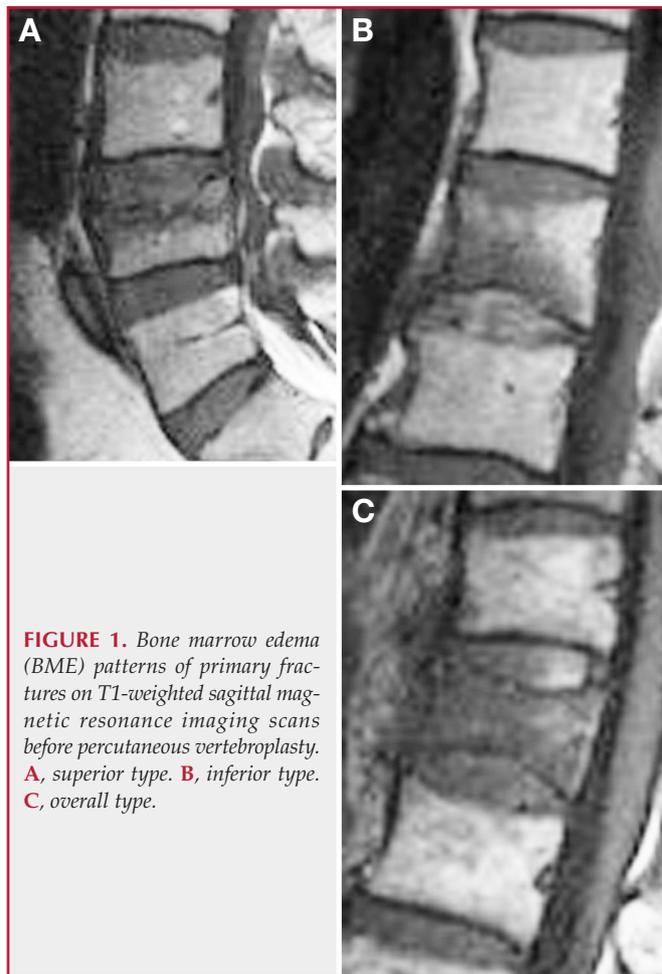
Bone marrow edema (BME) patterns of primary fractures on T1-weighted sagittal magnetic resonance imaging scans before percutaneous vertebroplasty. A, superior type. B, inferior type. C, overall type.
